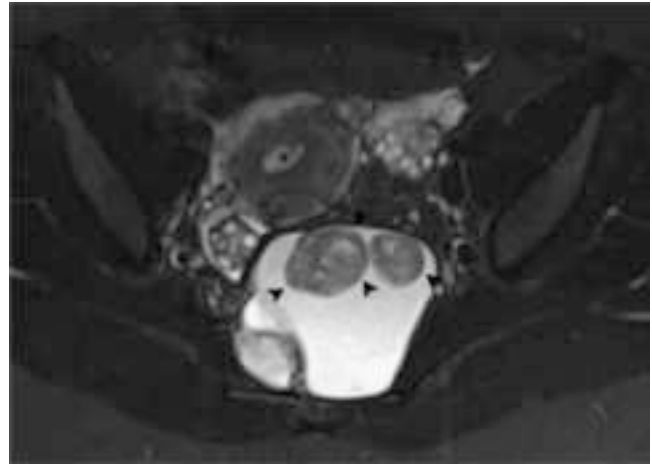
MRI of presacral cyst. T2-weighted imaging of an epidermoid cyst shows a bilobulated cystic lesion with pools of keratin debris (arrows) inside the larger cyst (Reprinted Loock MT, Fornès P, Soyer P, Rousset P, Azizi L, Hoeffel C. MR imaging features of nongynaecologic cystic lesions of the pelvis. *Clin Imaging* 2013;37(2):211–8 © 2013 Elsevier Ltd, with Permission from Elsevier. [31]).
